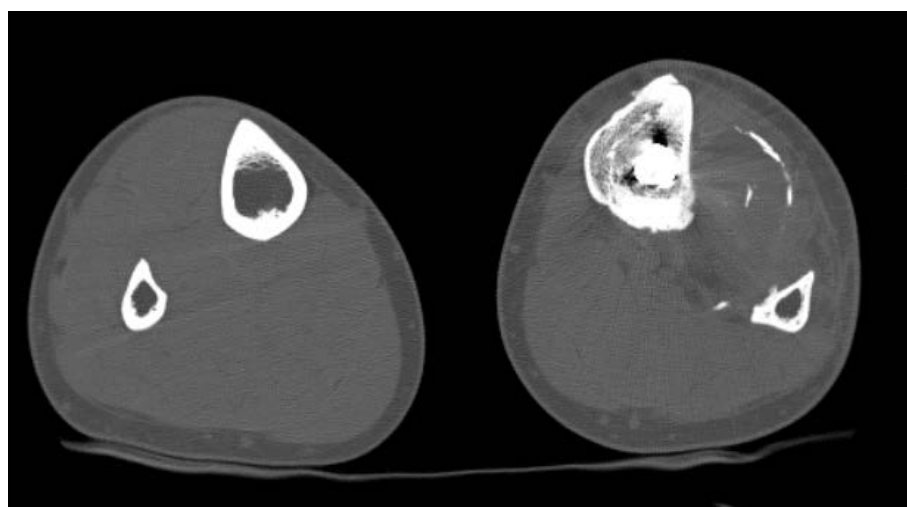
Computed tomography revealed a heterogeneous lesion at the pseudarthrosis site with calcified margins, raising suspicion of a soft tissue or bone neoplasm (4,2x2.5x6.2cm).
